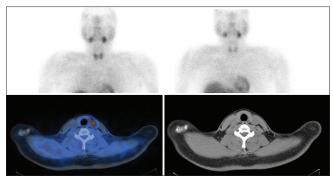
^{99m}Tc-sestamibi scintigraphy images of a 34-year-old male patient with recurrent primary hyperparathyroidism with no obvious parathyroid lesion visible. SPECT/CT images demonstrating nonlocalization of culprit lesion (bottom row). SPECT/CT: Single-photon emission computed tomography/computed tomography
